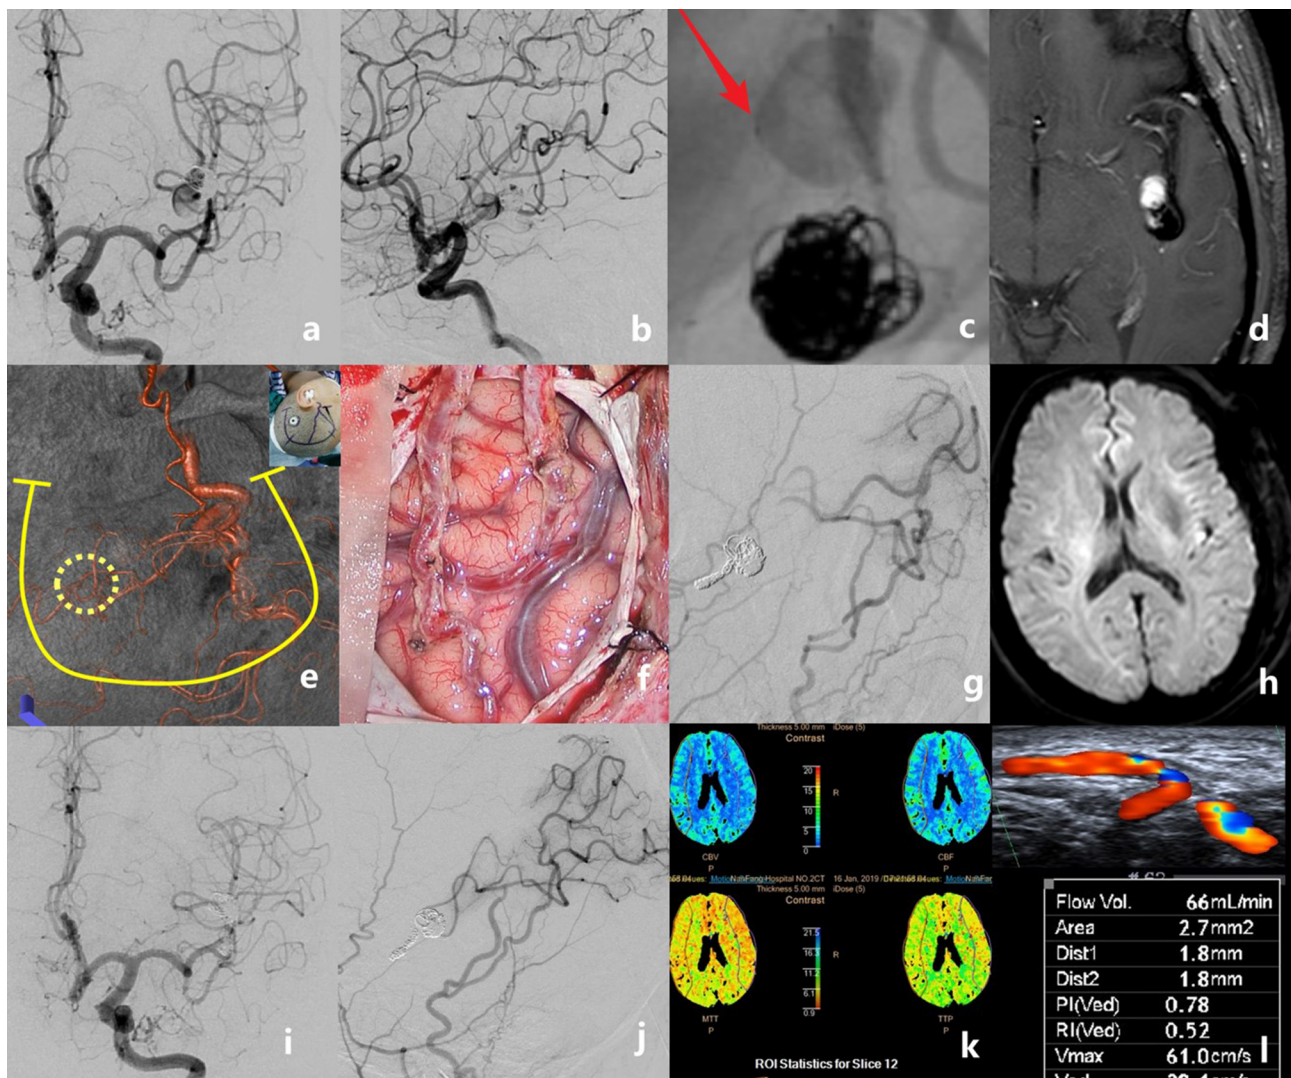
The case of a middle-aged patient with a recurrent middle cerebral artery (MCA) aneurysm after stent-assisted coil embolization is presented. Preoperative angiograms showed that the aneurysm was located at the inferior trunk of the left MCA [(a), anteroposterior view; (b), lateral view]. The stent deformation-related vascular injury developed into a new dissection just proximal to the previous coiled aneurysm (c). Pre-operative MRI showing the intra-aneurysmal enhancement (d). Recipient and donor vessels were precisely marked on the surface of the skull, then a U-shaped flap with a small bone window was designed (e). Double superficial temporal artery (STA)–MCA bypass was performed (f). Intraoperative angiography showed the patency of anastomoses; the aneurysm and the parent artery were embolized with coils (g). No new infarct was detected on the post-operative diffusion-weighted imaging (h). Digital subtraction angiography follow-up at 6 months revealed the total obliteration of the aneurysm and the good patency of grafts (i,j). Perfusion CT showed no ischemic area in the bypassed hemisphere (k). The graft flow was 66 ml/min (l).
